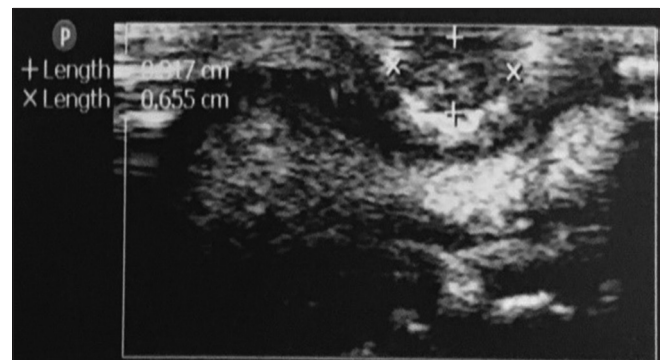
Image of the ultrasound showing irregular isoechoic region surrounded by the hypoechoic area
